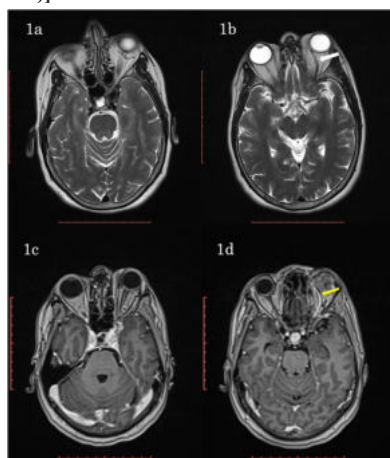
MRI brain T2 weighted axial images showing enlarged left CS with multiple signal voids in the region of left CS (a). Left SOV is dilated (white arrow) with proptosis of left eye (b) . Post contrast axial images (c & d) showing intense enhancement of left CS and dilated left SOV (yellow arrow).
